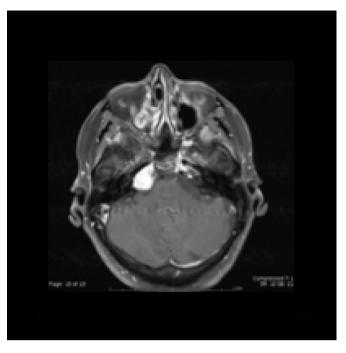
Axial T1-weighted MRI with gadolinium enhancement of Patient 1 showing the same lesion avidly enhancing.
